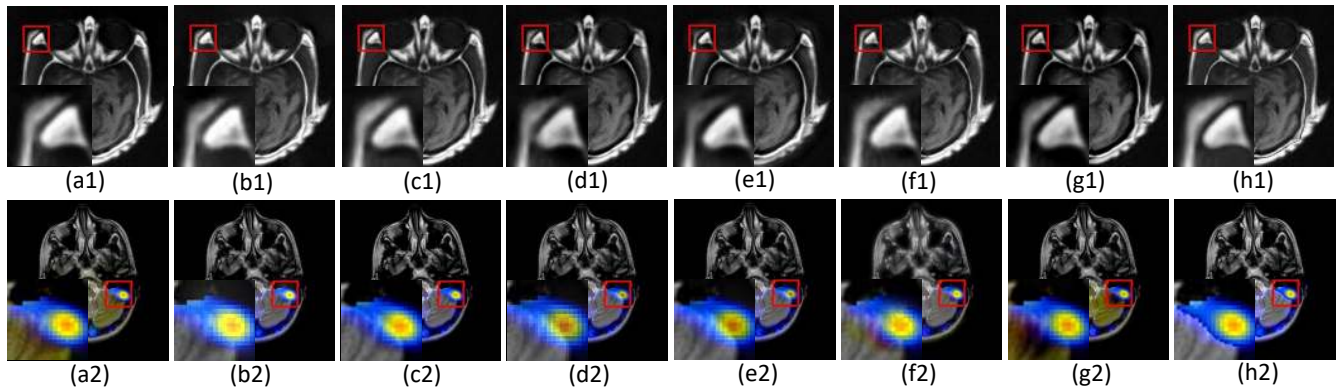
The cropping results of three types of fusion images : (a1)-(h1) CT-MRI fused images;(a2)-(h2) MRI-SPECT fused images;(a3)-(h2) MRI-PET fused images. Fused images (a1),(a2)is LP-SR based method;(b1),(b2)CNN based method;(c1),(c2)CFL based method;(d1),(d2) NSST-PAPCNN based method;(e1),(e2) NSCT-PC-LLE based method;(f1),(f2) LRD based method;(g1),(g2) NSCT-SR based method;(h1),(h2) the proposed method.
